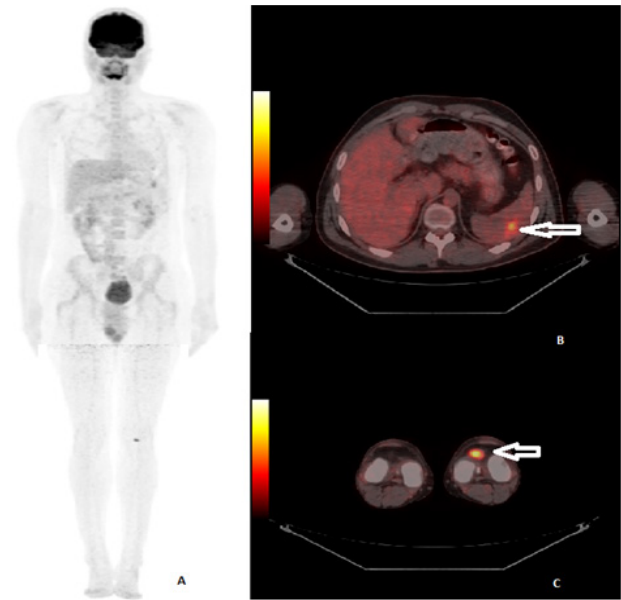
18F-FDG PET/CT scan after gemcitabine-irinotecan treatment A) MIP images, B) splenic lesion (white arrows).
